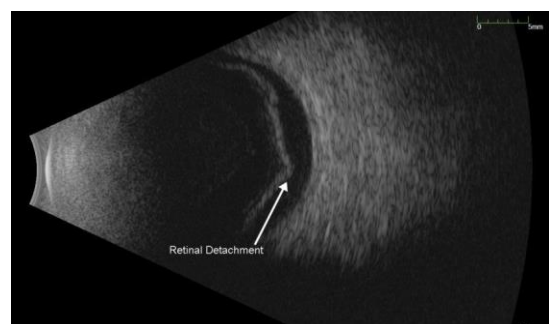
Ultrasonographic image (seagull sign) of retinal detachment
